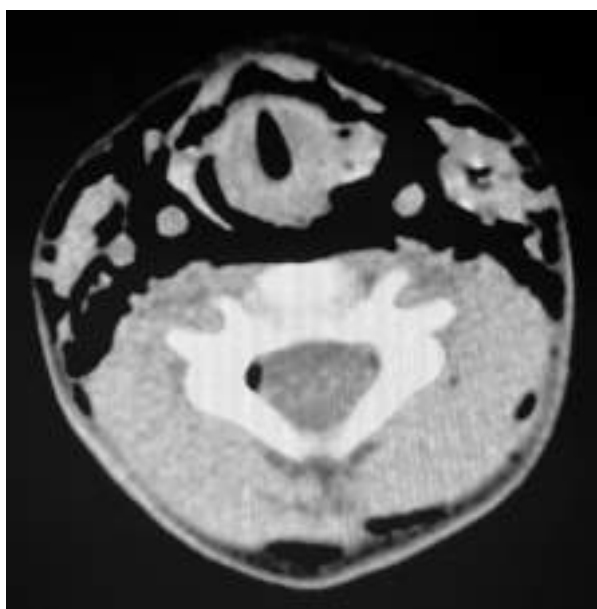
CT of the infrahyoid neck shows pneumorrhachis
